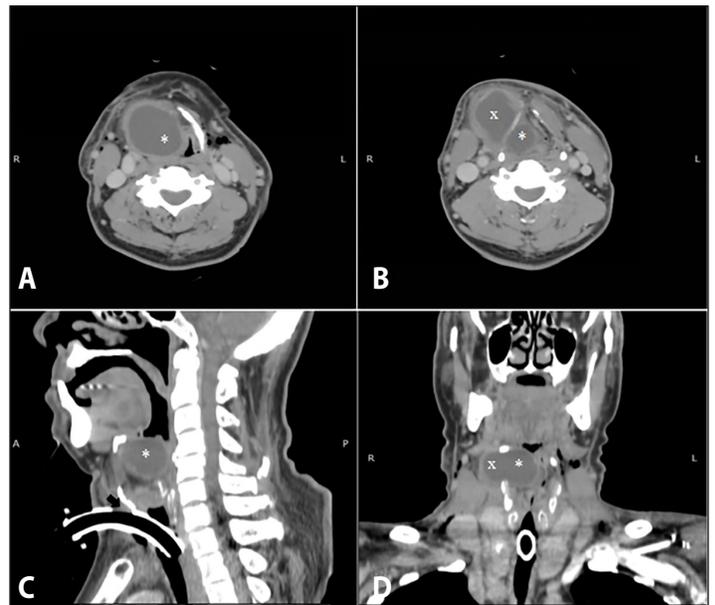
Computed tomography (CT) scans with contrast of the neck: A. axial view showing a well-defined, homogenous, hypodense, non-enhancing mass (asterisk), with peripheral rim enhancement in the right supraglottic area measuring 4.7 x 4.5 x 4.8 cm (AP x T x CC); B. axial view showing extralaryngeal component (x); C. sagittal cut showing the fenestra of tracheostomy tube outside the tracheal lumen (arrow); and D. coronal cut showing intralaryngeal (*) and extralaryngeal (x) components.
